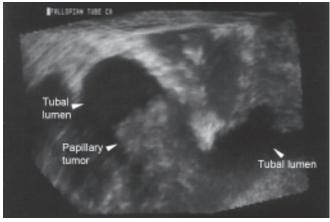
Three-dimensional ultrasound image of primary fallopian tube carcinoma. Papillary protrusions suggestive of fallopian tube malignancy are clearly seen within the distended tubal wall
